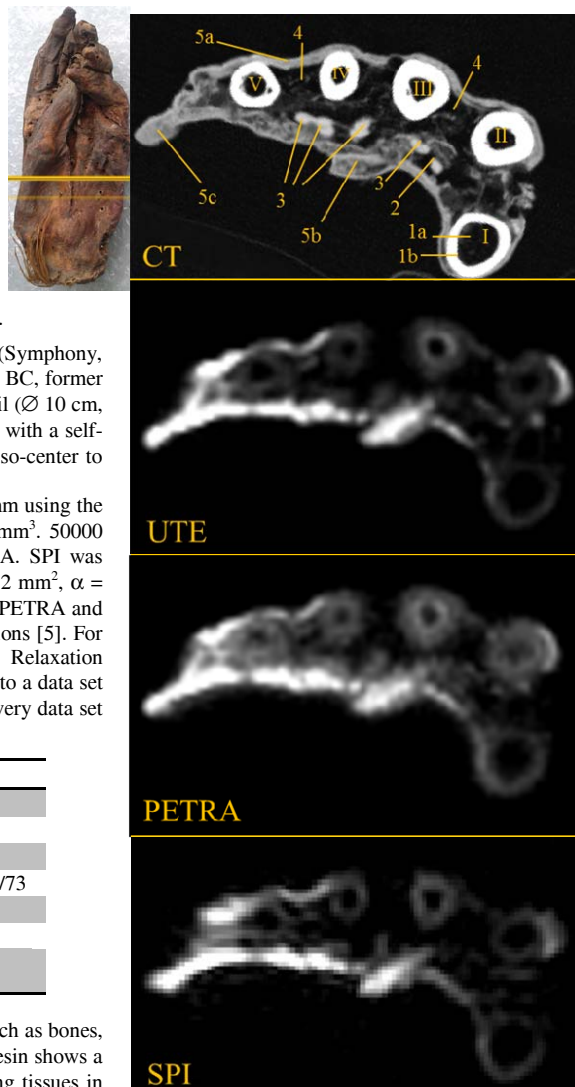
CT and MR images corresponding to the slice shown in the photo of the mummified hand. Significant structures are labeled on the CT image. See Table 1 for structural descriptions and local SNR calculations.
